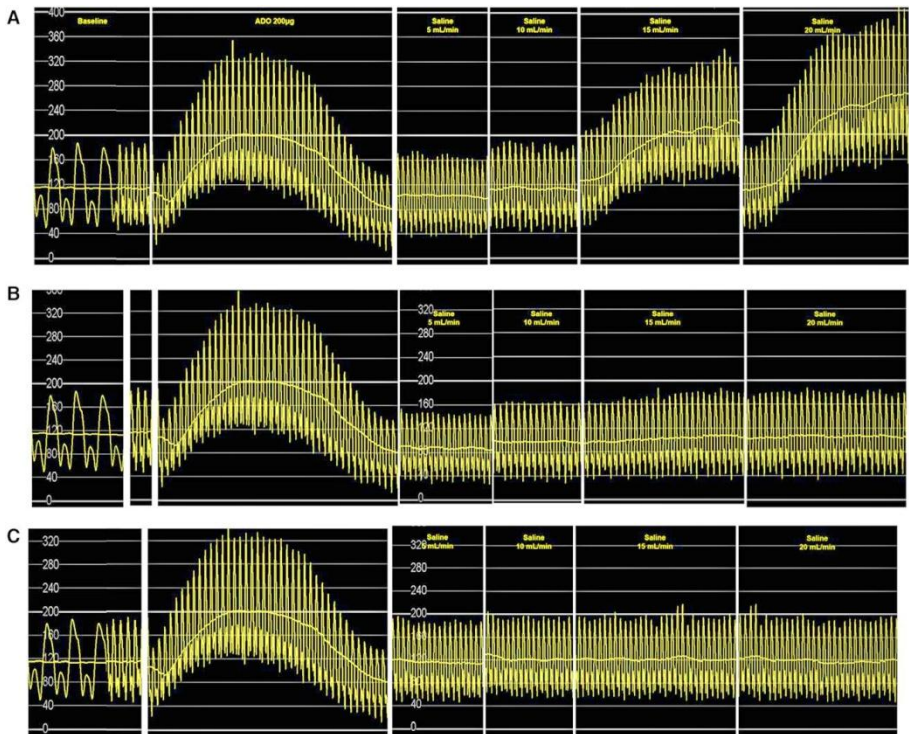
Representative example of coronary flow velocity tracings at baseline and after an intracoronary bolus of 200  $\mu$ g of adenosine, during infusion of saline at room temperature at rates of 5, 10, 15, and 20 mL/min. A, Saline is infused through the side holes of the catheter advanced over the Doppler wire. B, Saline is infused through the distal hole of the catheter advanced over the Doppler wire. C, Saline is infused through the side holes of an infusion catheter advanced in a contralateral artery.
